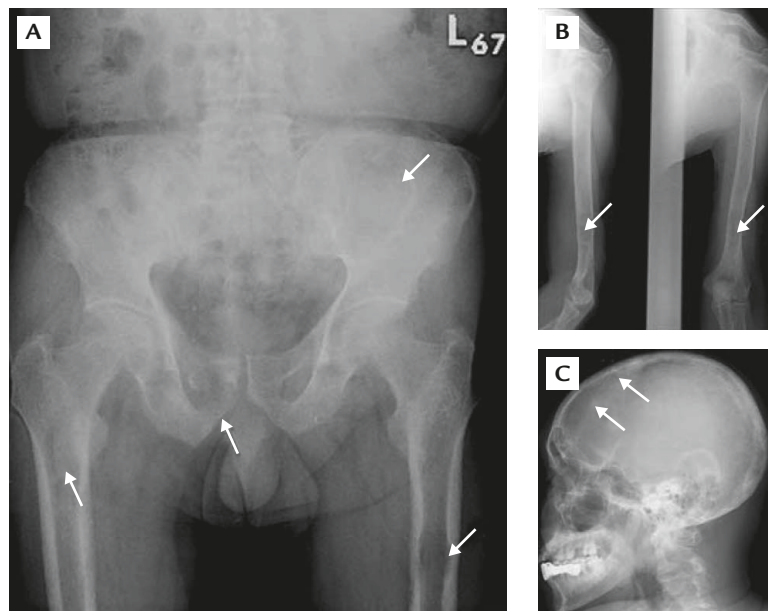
Multiple osteolytic lesions on X-ray examination. (A) Lesions in proximal femurs and pelvic girdle (arrows). (B) Lesions in left humeral shaft (arrows). (C) Typical salt-and-pepper pattern of brown tumor on the skull (arrows).
